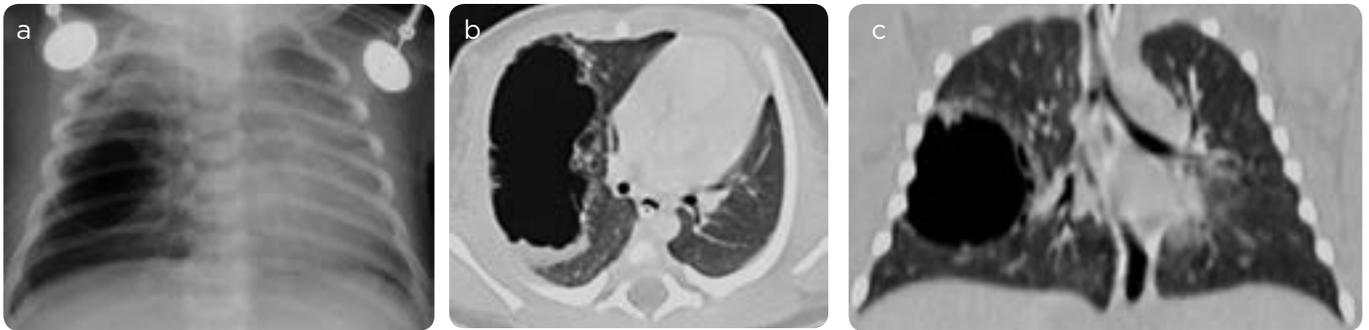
Type 1 cystic adenomatoid malformation. 5-day-old girl. a) Chest X-ray. Radiolucent image of round morphology and thin wall in the right lung. b and c) CT scan of chest, axial and coronal reconstruction. Cystic lesion in the middle lobe, lobed contours and thick wall.
